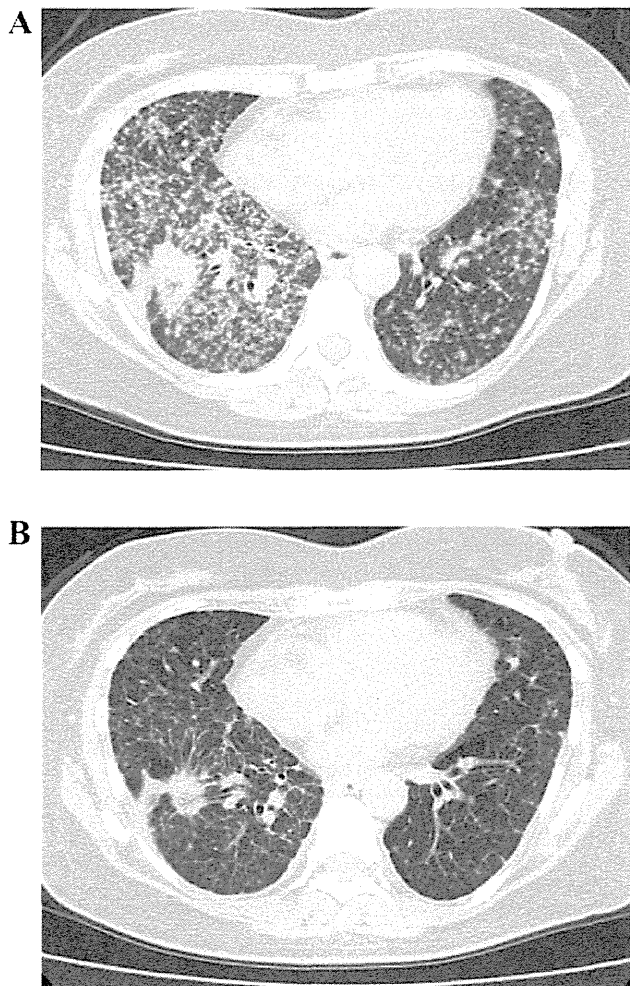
Dramatic effect of EGFR-TKI for a poor PS *EGFR* mutant. A chest CT scan obtained before treatment (A) and at 2 weeks after the administration of erlotinib (B) are shown. The diffuse granular shadow of the bilateral lung field had mostly disappeared after the initiation of therapy. Consequently, the patient's PS score improved from 3 to 1.
